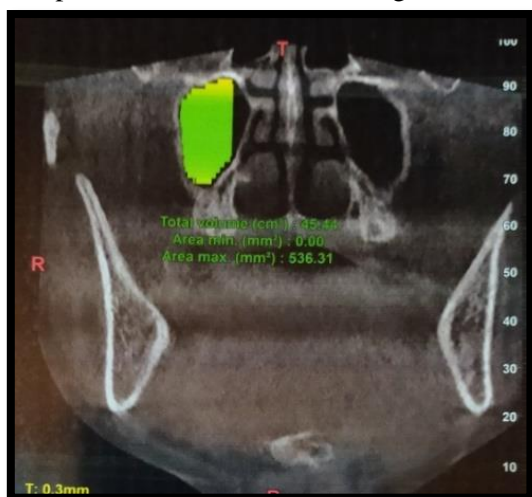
Coronal Section of CBCT
